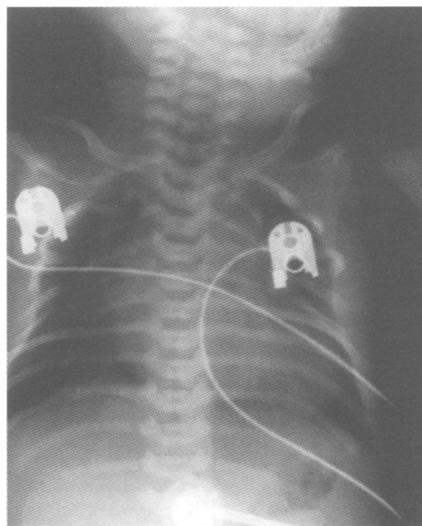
Chest radiograph showing multiple rib gaps.
